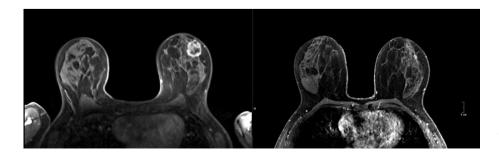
MRI images before and after neoadjuvant chemotherapy in patient candidate to BCS post NACT. All patients received neoadjuvant treatment according to AC/EC/FEC scheme for 3-4 cycles every 21 days followed by weekly Paclitaxel for 12 cycles. In cases of HER2 positivity, biological therapy with Trastuzumab was initiated prior to surgical intervention. All hormone positive cancers, except for particular contraindications, started hormone therapy at the end of chemotherapy.
